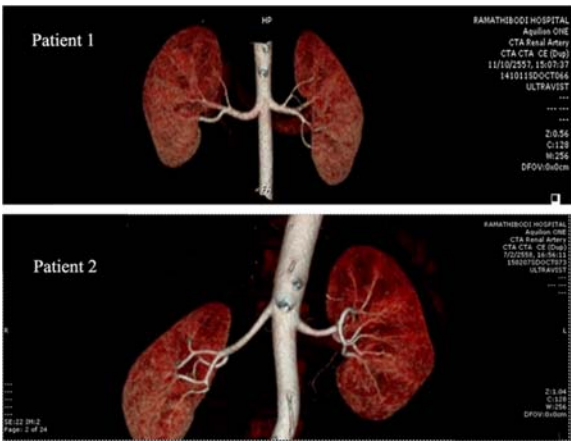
Computed tomography arteriograms of both donors.
